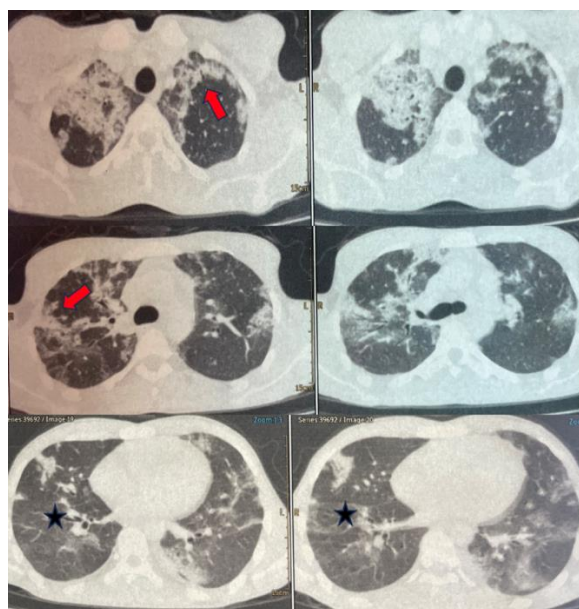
CT scan demonstrates areas of airspace consolidation with peripheral predominance (see arrow) and ground glass opacities (see stars)
